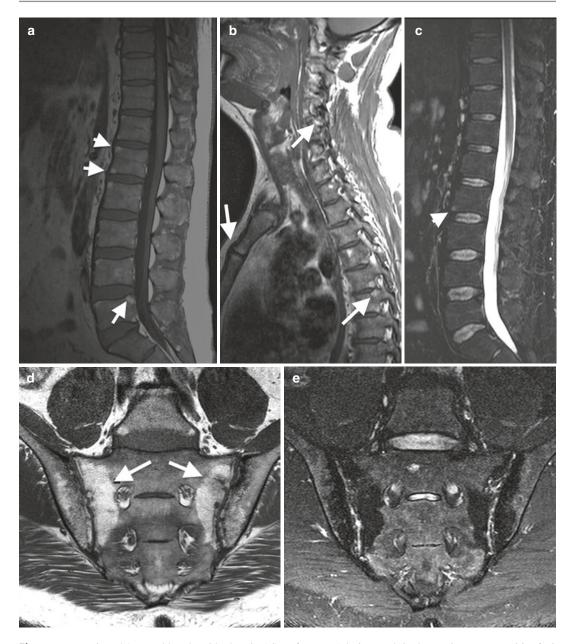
MRI in a 45-year-old male with chronic AS, (a) Sag T1 of the lower spine with multiple corner postinflammatory fat accentuation, PIFA (*arrows*); (b) Sag T1 of the upper spine with similar changes with additional PIFA related to the manubriosternal joint and cervical facet joint; (c) Sag T2 of the lower spine with loss of SI
